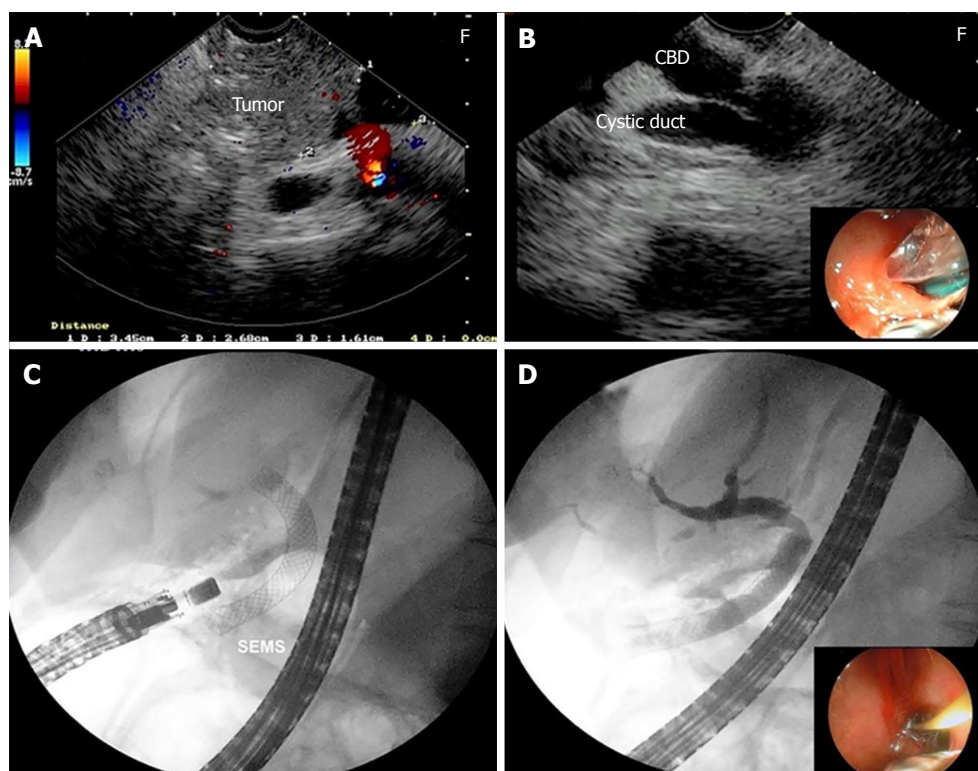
Endosonography-guided choledochoduodenostomy. A: Endosonography (EUS) image of the pancreatic carcinoma; B: Puncture of the common bile duct through the duodenum with a 19 gauge aspiration needle; C: Insertion of the self-expandable metallic stents after balloon dilation of the fistula; D: EUS-guided cholangiography through the choledochoduodenostomy.
